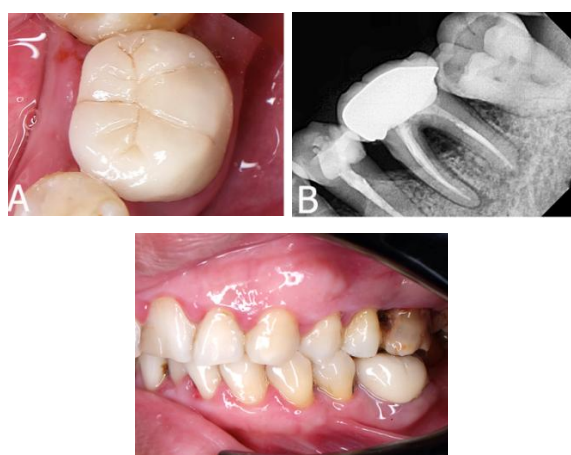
Cementation of the porcelain-fused-to-metal crown restoration (A), radiographic confirmation (B), and occlusion after restoration (C)
